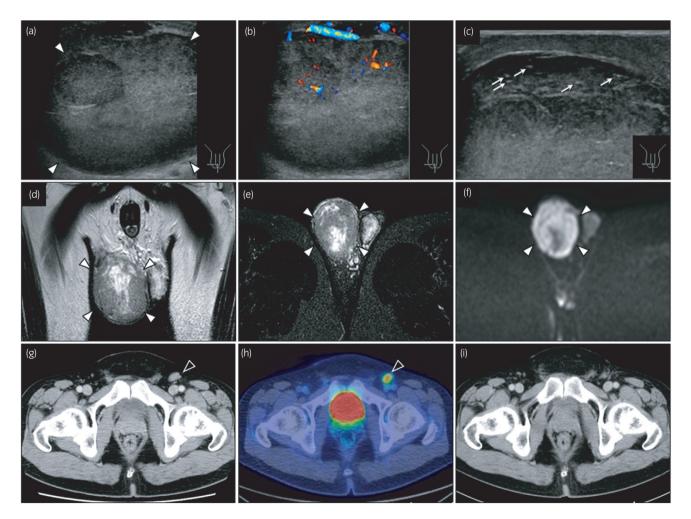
Ultrasonography shows a well-defined, $76 \times 40 \times 53$ mm mass (white arrowhead) with abundant blood flow in the right scrotum (a and b). Scattered hyperechoic foci (white arrow) are observed in the bilateral scrota, indicating testicular microlithiasis (c). Magnetic resonance imaging shows mosaic-pattern intensity in the enlarged left scrotum on T2-weighted images (d) and fat-saturated T2-weighted images (e). Heterogeneous diffusion restriction is suggested on diffusion-weighted images (f). A follow-up CT performed 2 years after treatment reveals an enlarged left inguinal lymph node (g), demonstrating increased ¹⁸F-fluorodeoxyglucose uptake on positron emission tomography (h). There is no sign of recurrence on the following CT 4 years after the second surgery (i).
